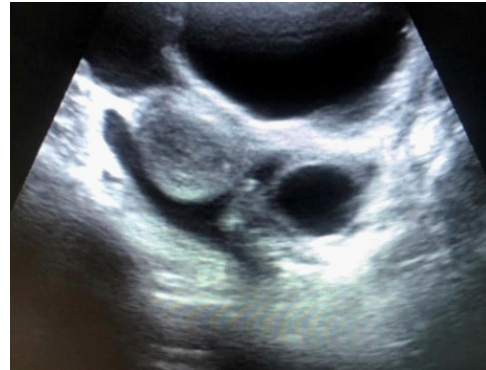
Transabdominal sonography showing ruptured Graffian follicle
